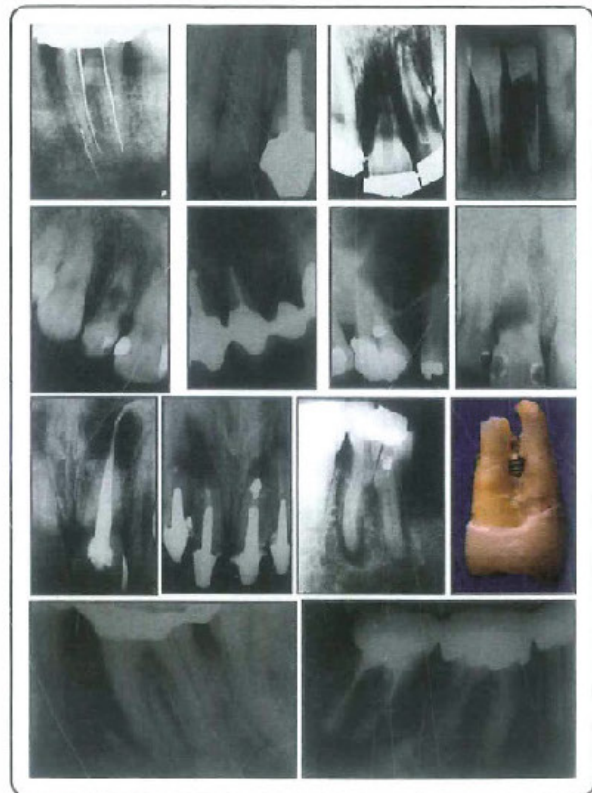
Radiographs showing some of the conditions that require surgical intervention
